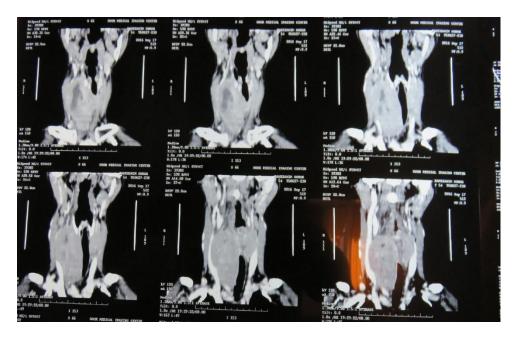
CT scan is shown with a preoperative diagnosis of anaplastic thyroid carcinoma.
